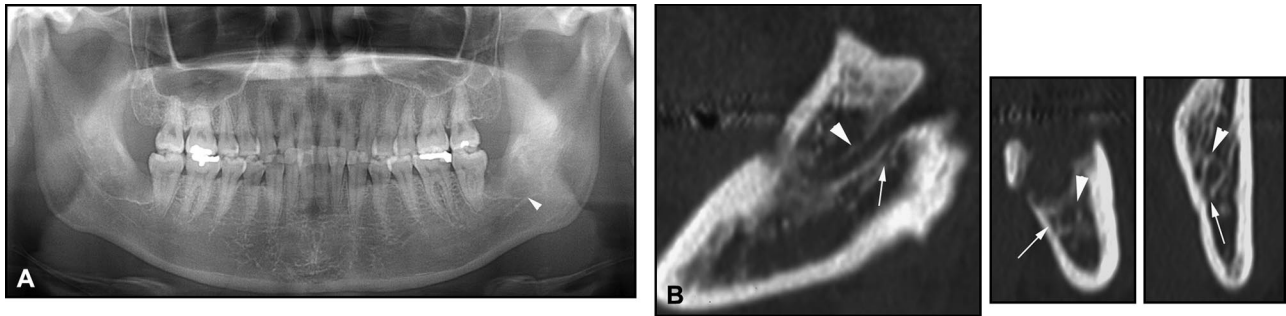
Radiographs of patient 3. A, Panoramic image. B, Reconstructed CT images in the left side. On the panoramic image, the bifid mandibular canal did not appear. On the reconstructed CT images of the left mandible, there was a single mandibular foramen and narrow lower canal toward the distal area of the second molar after the bifurcation.
